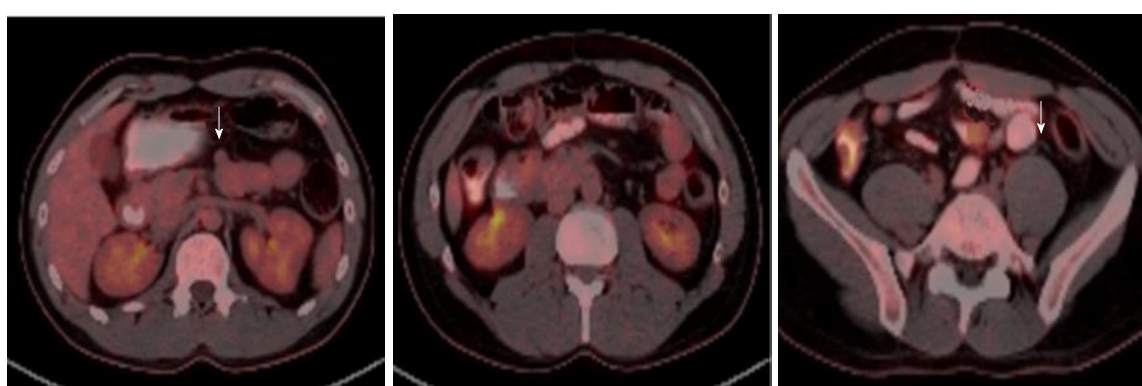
^{18}F -fluorodeoxyglucose positron emission tomography-computerized tomography scans of the gastrointestinal stromal tumors recurrence. Serial ^{18}F -FDG PET-CT scans showed submucosal, solid lesions in jejunum (SUVmax: 1.68-1.50) (A, B) and ileum (SUVmax: 4.69) (C) with maximum 2 cm in diameter, consisted with GIST recurrence on the follow-up (arrows). ^{18}F -FDG: ^{18}F -fluorodeoxyglucose; PET-CT: Positron emission tomography-computerized tomography; GIST: Gastrointestinal stromal tumors.
